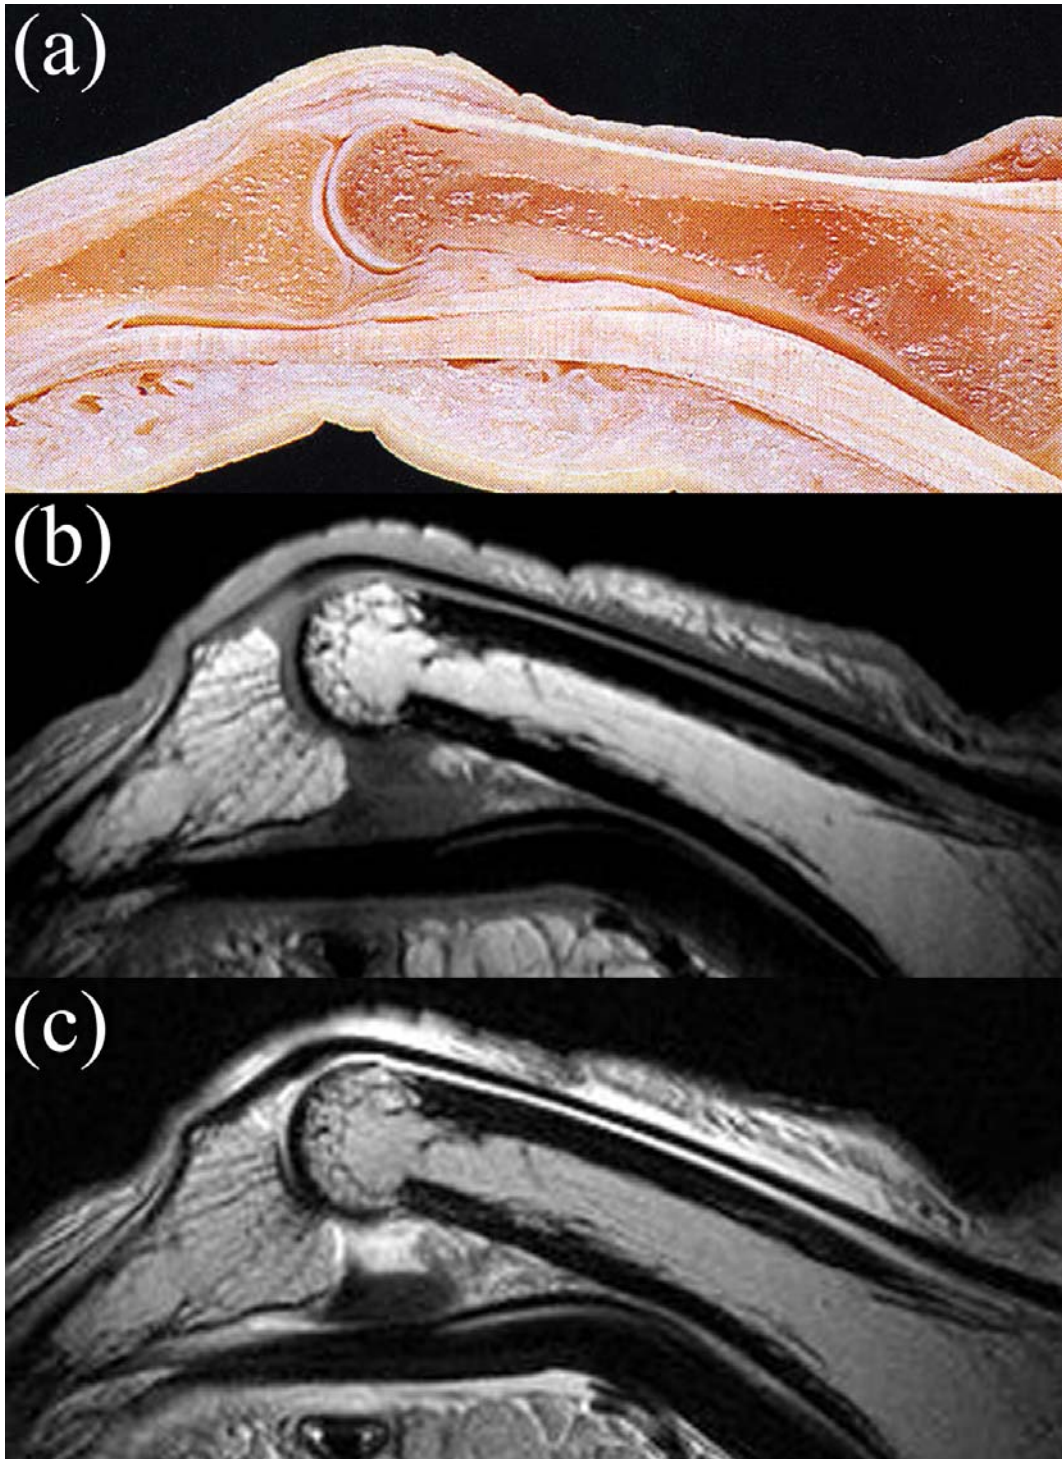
(a): Photograph of a sliced finger. (b): T1 and (c): T2 weighted MRI of finger.
